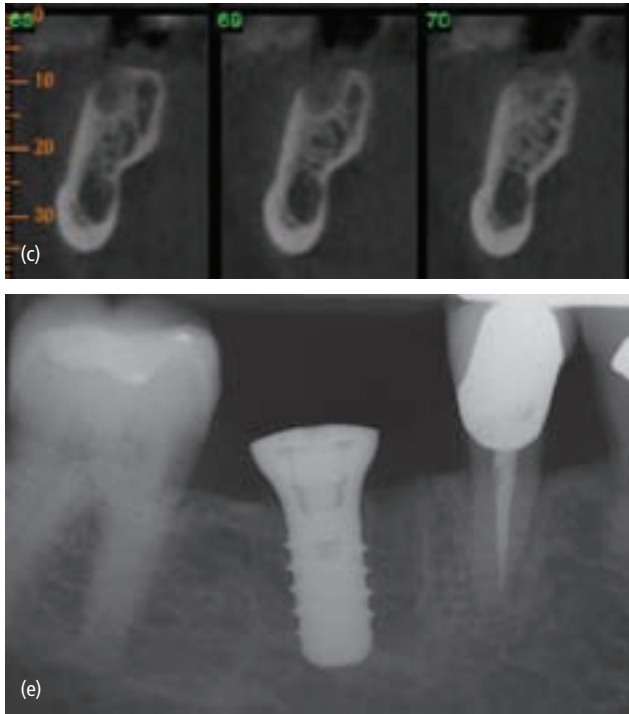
(cont'd) (c) A CT image was taken and placed into a computer-aided navigation device. Following planning this device was used during implant placement. (d) Intraoperative radiographs were used to verify the position. (e) The implant was placed without raising a flap and (f) later restored.
